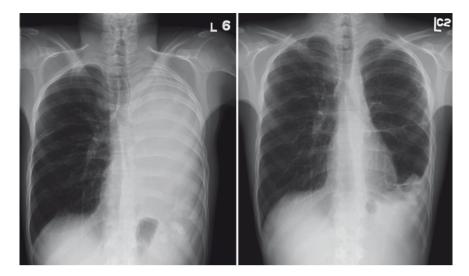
Chest radiograph of patient who responded to four courses of Ifosafamide 17.5  $G/m^2/$  course administered over 5 days (3.5  $G/m^2/dx5$ ). The patient had previously been treated with, and responded to, Ifosfamide 14  $G/m^2$  and later relapsed
